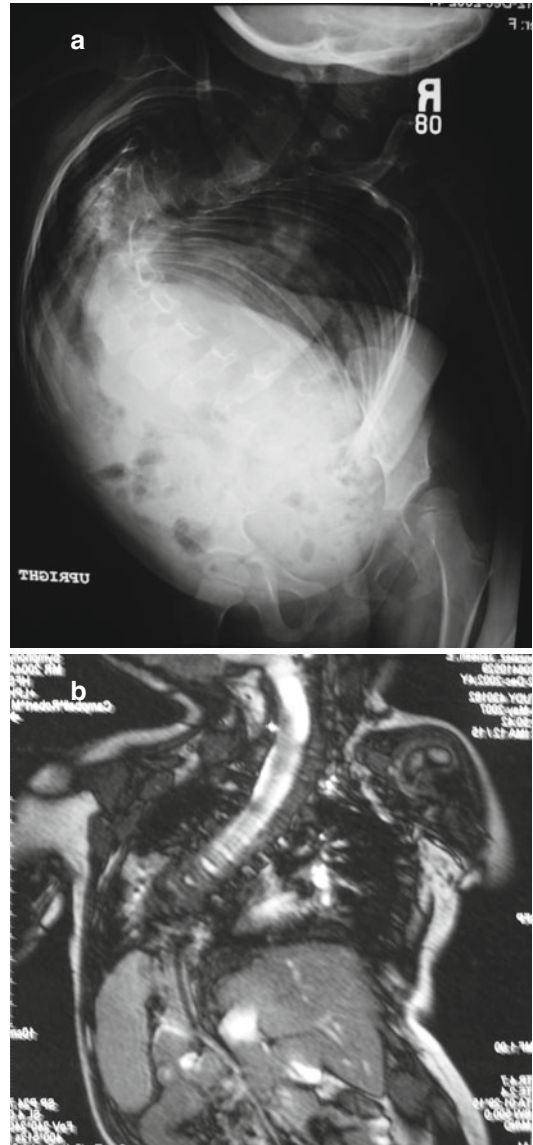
(a) Severe scoliosis. (b) AP dynamic lung MRI of the thorax. Note intrusion of the liver into the chest from the iliac crest malposition, obstructing diaphragmatic motion
